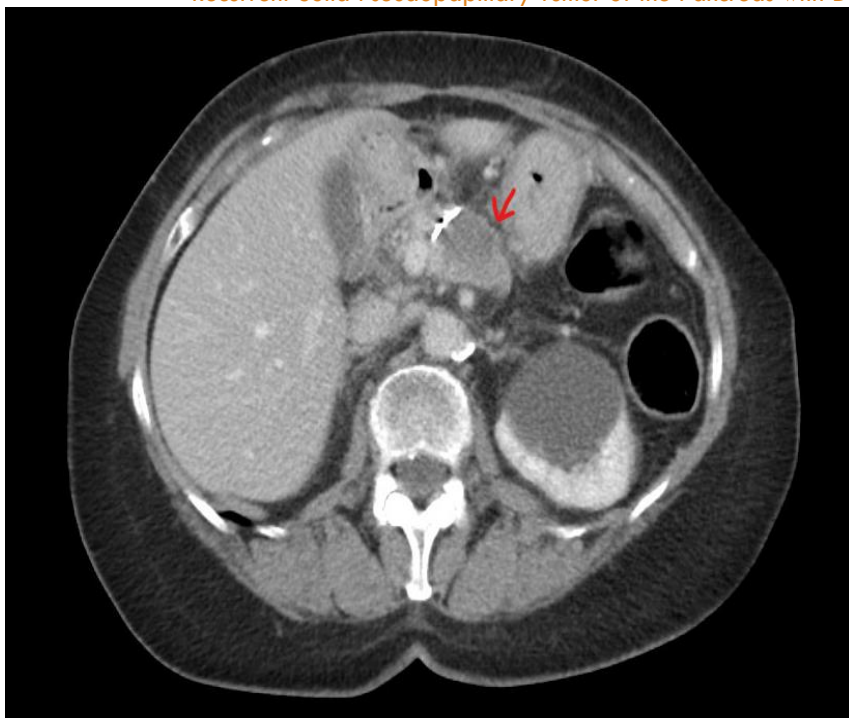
CT After Initial Radiation Therapy Demonstrating a Plane between the Pancreatic Component of the Recurrence and the Fundus (Red Arrow)
